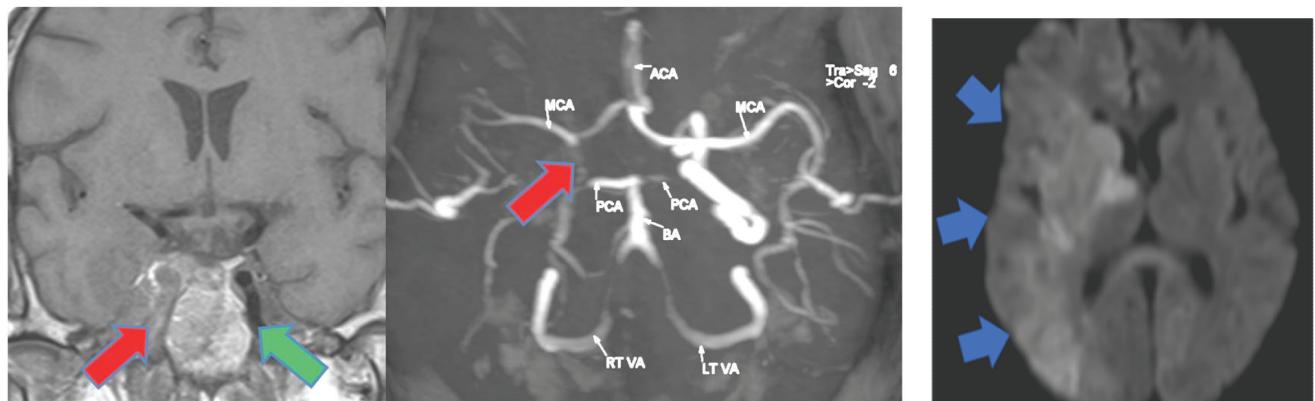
Right ICA occlusion: T1W coronal image show no flow void at right ICA at precavernous/cavernous segment (Red arrow); compare with normal left side. MR angiography show no flow signal at right ICA (Red arrow). Note the extensive right MCA territory infarct at right brain on DWI images (blue arrows).
